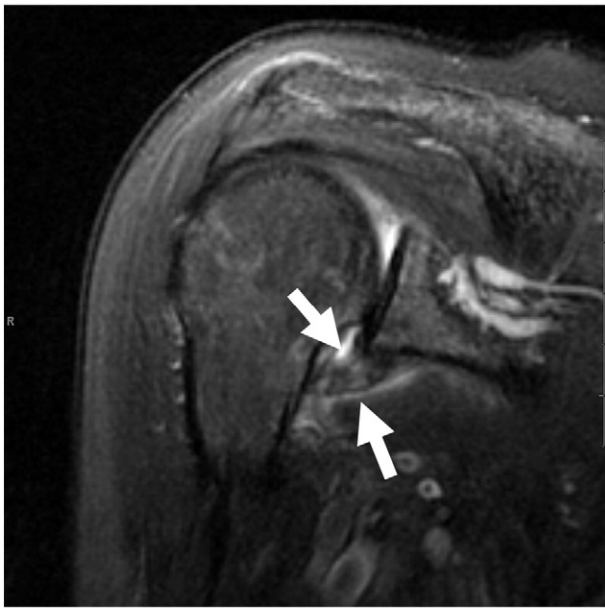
A 53-year-old woman with clinical adhesive capsulitis. Coronal oblique T2-weighted fast spin echo fat suppressed sequence shows thickening and edema of the axillary recess (white arrows).
